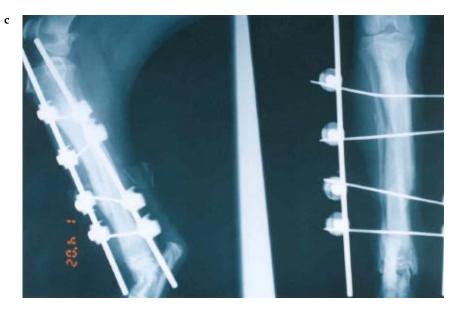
Radiography of midshaft *tibia-fibula* fracture belonging to a Siberian husky, using external fixator with closed reduction. a – before surgery, b – immediately after surgery, c – appearance 22 days after surgery showing problem-free healing
